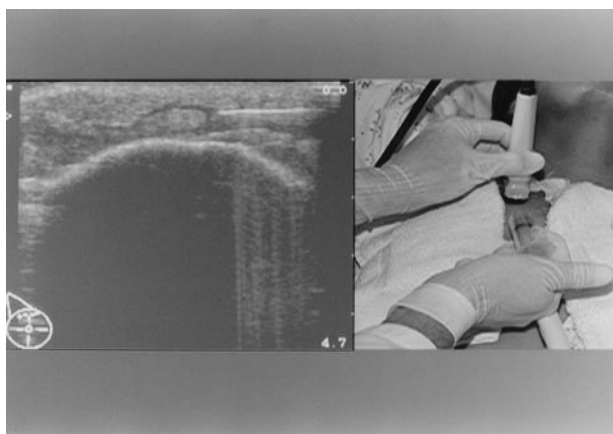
Cryoablation of breast cancer. Ultrasound is used to monitor the creation of an ice ball, which engulfs the cancer, destroying the targeted area.
